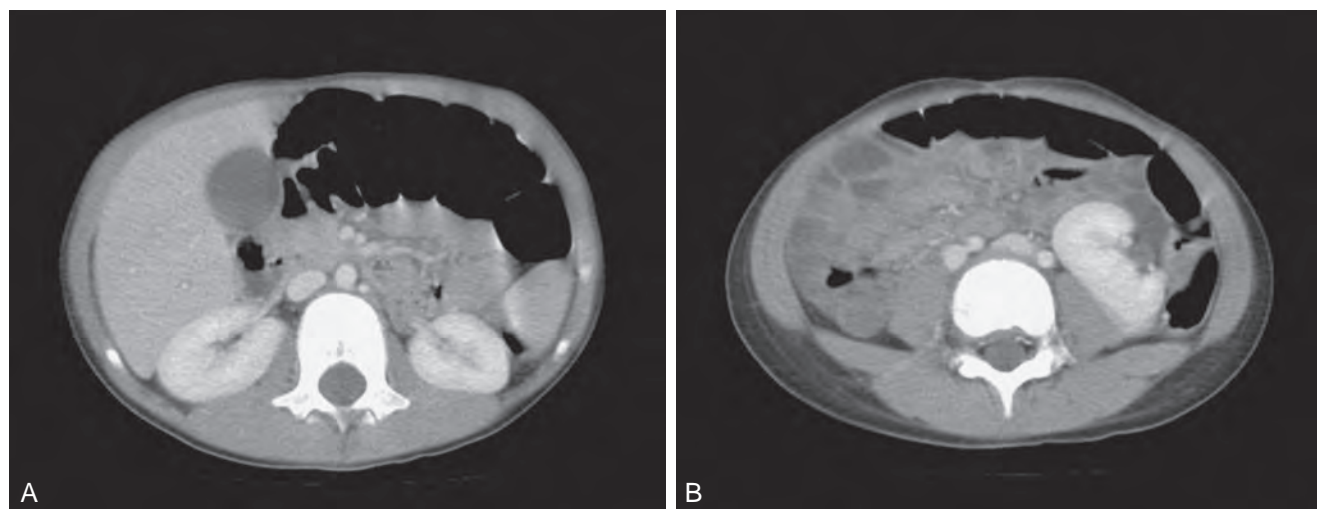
Contrast computed tomography scan showing (A) right and left orthotopic kidneys. B, Right midabdominal malrotated supernumerary kidney.
